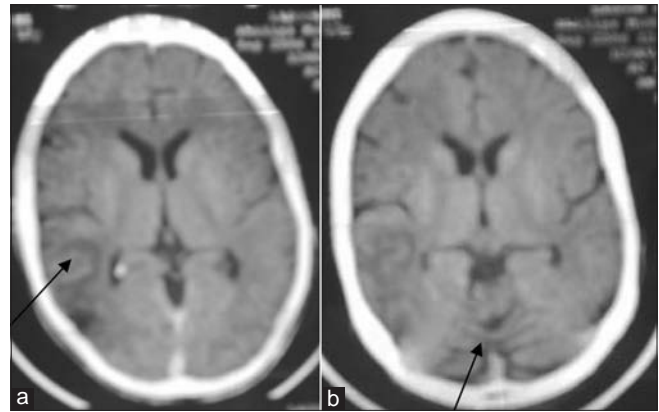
Computed tomograms of the patient. (a) Wedge shaped hypodense non-enhancing lesion in the right parietal lobe. (b) Prominence of ventricles with widening of the cerebellar sulci
